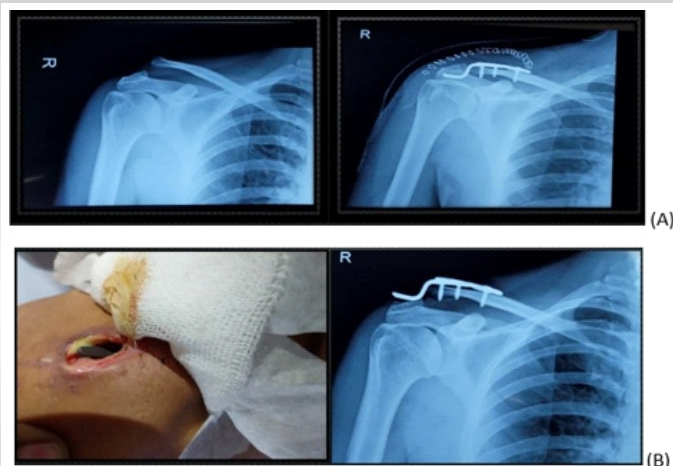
Image series showing clinical picture (a) and the X-ray of the right shoulder antero-posterior view (b) revealed a dislocated acromio-clavicular joint with a displaced and failed hook plate in situ.
